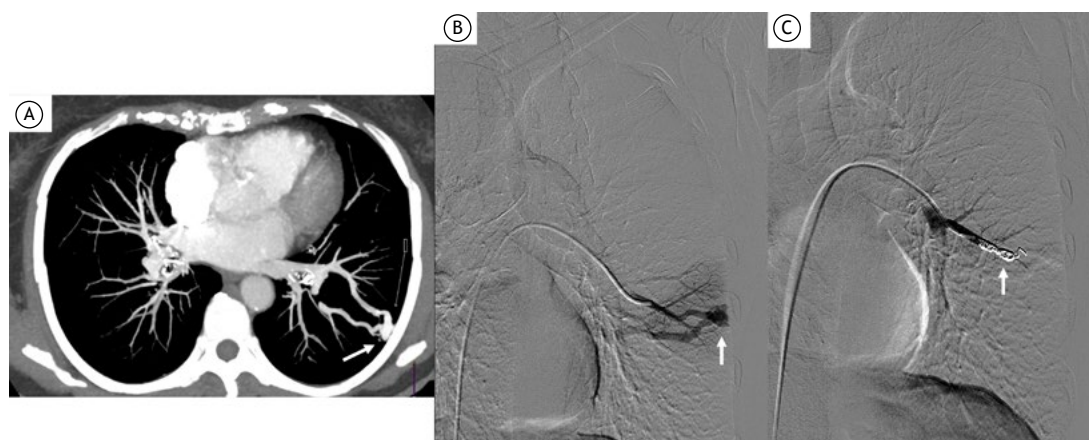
In A, a CT scan demonstrating peripheral pulmonary arteriovenous malformations (white arrow). In B, localization of the malformation by pulmonary angiography (white arrow). In C, embolization with coils (white arrow).
